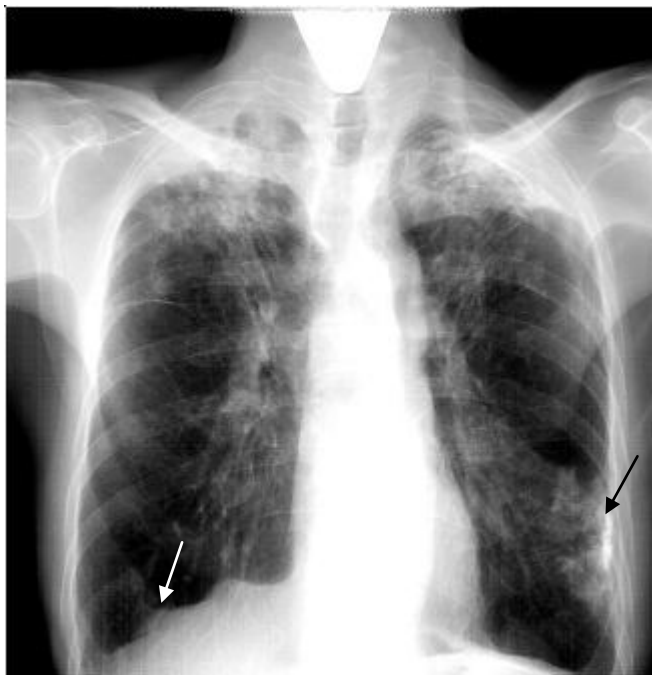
The frontal chest radiograph. Extensive non-homogeneous intensive shadow in both pulmonary fields, mainly in the upper parts, due to numerous nodules, fibrosis and pleural layers. Hila are shifted up. On the left at the level of the anterior departments of the VI-VIII there is intensive, non-uniform calcined shadowing (black arrow). The the right the diaphragmatic cupula is deformed by pleuro-diaphragmatic commissures (white arrow). Right dome of the diaphragm is deformed by pleura-diaphragm adhesions (white arrow). Cicatrization atelectasis upper lobes due cirrhotic tuberculosis of both lungs. Calcification of the pleura on the left
